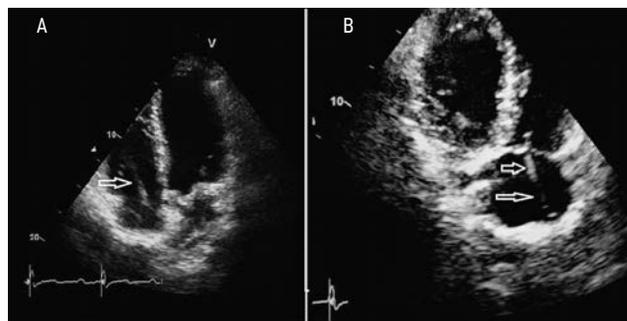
Echocardiograms of patient A. Arrows indicate uneven compaction and thickening of the electrode sections located in the right chambers of the heart. Reliable formations in the projection of the electrodes are not determined. A — Four-chambered apical section; B — Modified three-chambered apical section (through the inflow sections of the right ventricle).
